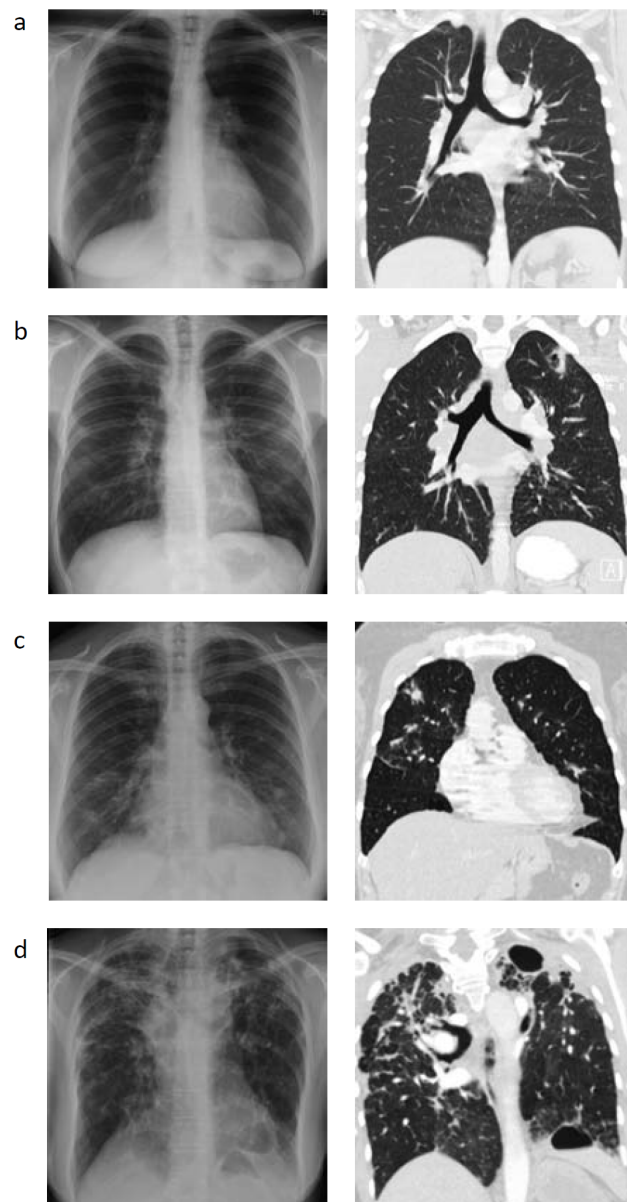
Chest radiographic staging system in sarcoidosis. a. Stage I : CXR (left) and coronal high-resolution computed tomography scan (HRCT; right) showing bilateral hilar lymphadenopathy, without parenchymal abnormalities. b. Stage II: CXR (left) and coronal HRCT image (right) showing both lymphadenopathy and parenchymal abnormalities (nodular and reticulonodular opacities). c. Stage III: CXR (left) and coronal HRCT image (right) showing parenchymal abnormalities without hilar lymphadenopathy. d. Stage IV: CXR (left) and coronal HRCT image (right) showing signs of lung fibrosis with hilar retraction and architectural distortion of the pulmonary parenchyma.
